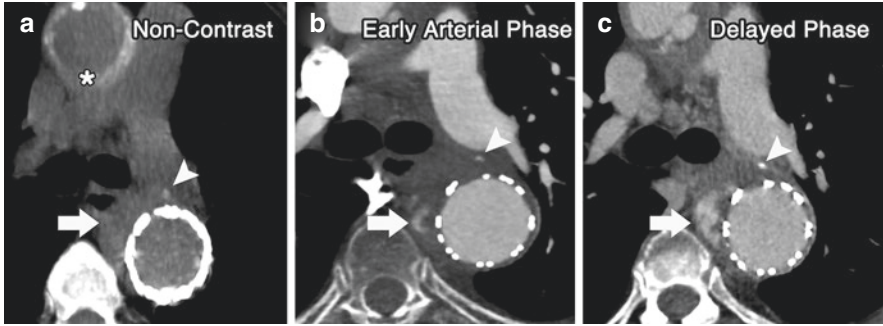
Post-Endograft CTA Technique*: Standard post-endograft CTA consists of a 3-phase imaging protocol. First, a non-contrast scan is performed (a) to clearly identify any dense objects such as the metallic endograft, surgical material (asterisk) or calcium (arrowhead). Second, contrast is administered and images are acquired in the early arterial phase (b), producing maximal aortic opacification and allowing identification of endoleaks (arrow). Lastly, a delayed phase is acquired (30–60 seconds after arterial phase) to allow detection of slow filling endoleaks and better depict the full extent of any endoleaks (arrowhead)
